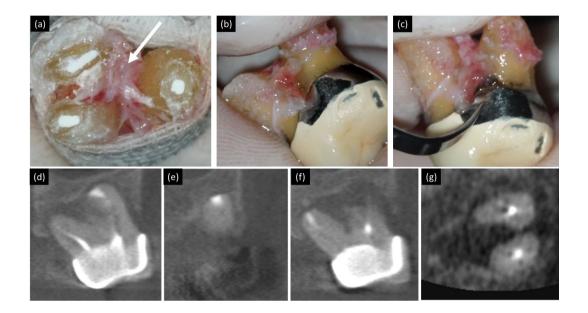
(a)~(c) : Extracted tooth and Diagnosis CBCT image (before extractionbone healing of apex and bone loss on furcation) on #27; (a) furcation (granulation tissue; white arrow) (b) mesial (c) distal view, (d)~(g) : Diagnosis CBCT image; (d) mesio-buccal root apex (e) disto-buccal root apex (f) palatal root apex (g) furcation.
